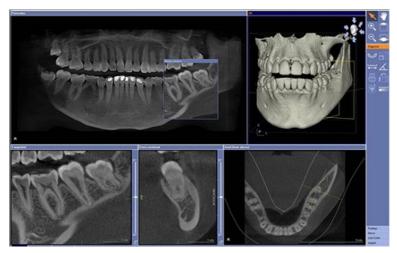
Isolation of individual fragments on 3-D images of a dental computed tomograph.
